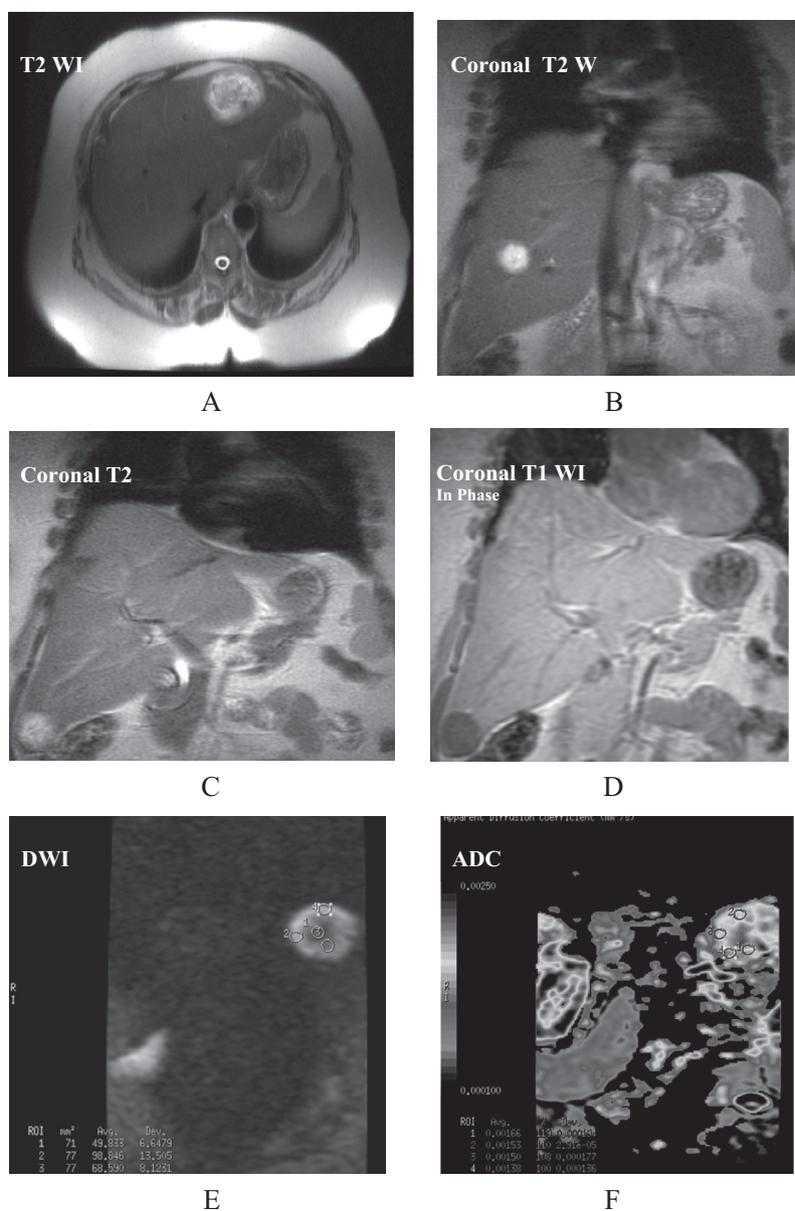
(A–F) Female patient aged 55 year presented with jaundice, epigastric pain and epigastric swelling with past history of cancer colon resection. MRI study revealed multiple hepatic focal lesions in both right and left hepatic lobes namely segment II of the left hepatic lobe and segment VIII & VI of the right hepatic lobe. All the lesions exhibit hypointense SI on T1WI, markedly hyperintense SI on T2WI & diffusion study (DWI) and hypointense on ADC map with mean ADC value = $0.9 \times 10^{-3} \text{ s/mm}^2$. The largest lesion in the left hepatic lobe exhibits only marginal restricted diffusion due to central necrosis with mean ADC value = $1.7 \times 10^{-3} \text{ s/mm}^2$. The diagnosis was established as metastatic deposits based on the clinical history and the MRI findings.
